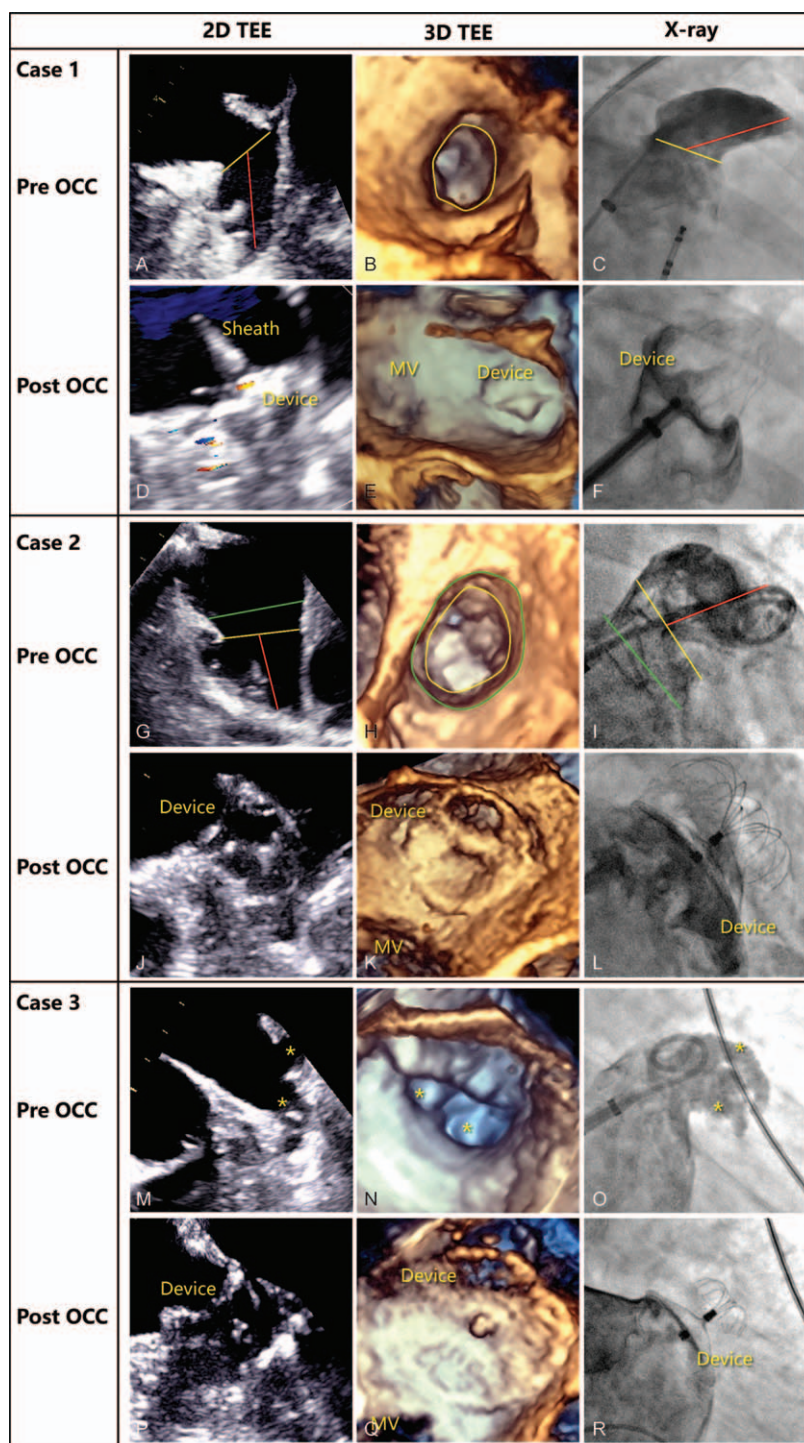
Strategies of closure for LAA with various morphologies. Case 1 was a patient with single-lobed LAA displayed by 2D TEE (A), 3D TEE (B), and x-ray (C), which showed a greater depth (red line) than ostium (line or circle in the yellow color) suitable for placement of Lefort device. The LAA was completely occluded with no significant leakage detected by 2D color flow imaging (D), 3D TEE (E), and x-ray (F). 3D TEE also indicated the anatomic relationship between the device and the mitral valve (E). Case 2 was also a single-lobed LAA with a limited depth comparing with the ostium. A regular LAMBre device was used for the closure. The landing zone (line or circle in the yellow color) and the ostium (line or circle in the green color) were measured prior to the procedure (G-I), and the closure was successful performed (J-L). Case 3 was a bi-lobulated (yellow star) LAA in 2D TEE (M), 3D TEE (N), and x-ray (O). The feature of this LAA was that there was a significant secondary lobe originating proximal to the main anchor lobe which was very challenging for occlusion. Then, a special LAMBre device was applied for occlusion. Both TEE and x-ray demonstrated full coverage of these two ostium of the LAA with no residual flow (P-R). 2D TEE = two-dimensional transesophageal echocardiography, 3D TEE = real-time three-dimensional transesophageal echocardiography, LAA = left atrial appendage, OCC = occlusion.
